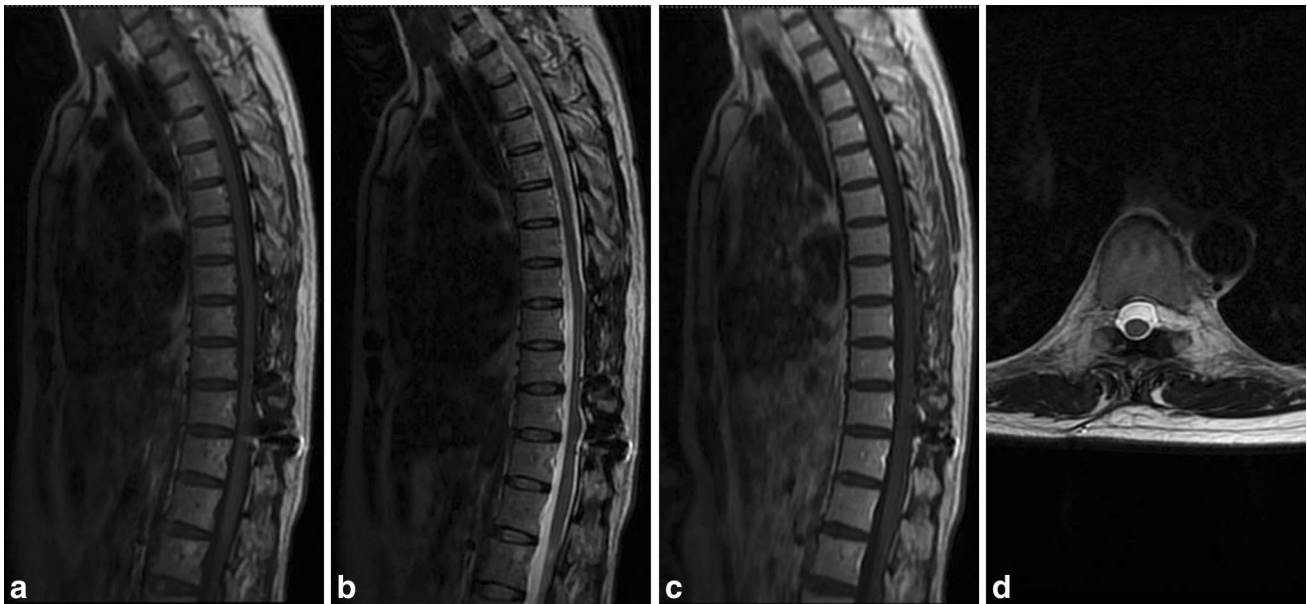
Two years after surgery, magnetic resonance imaging demonstrated no recurrence of tumor, and the spinal cord was decompressed (a T1-WI, b T2-WI, c contrast-enhanced T1-WI, and d coronary T2-WI)
